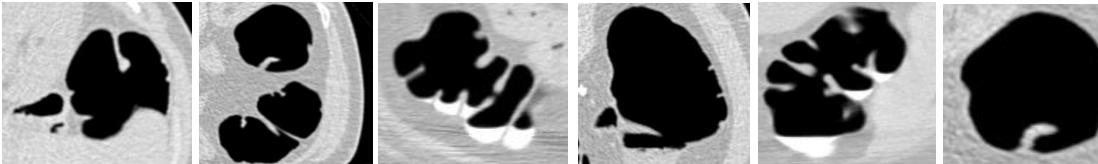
Original axial CT images
